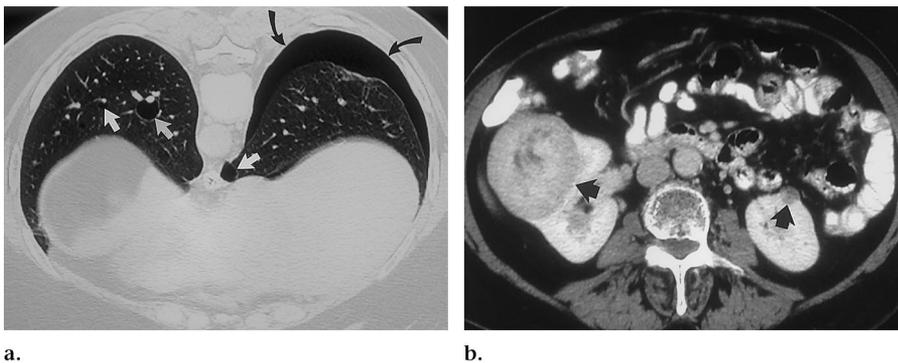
Birt-Hogg-Dubé syndrome in a 43-year-old man with a history of recurrent pneumothorax. Multiple fibrofolliculomas were present on the face. (a) Transverse chest CT image obtained with the patient prone demonstrates pneumothorax (black arrows) and several pulmonary cysts (white arrows). (b) Transverse abdominal CT image demonstrates bilateral solid renal cancers (arrows). Right-sided nephrectomy revealed chromophobe carcinomas.
